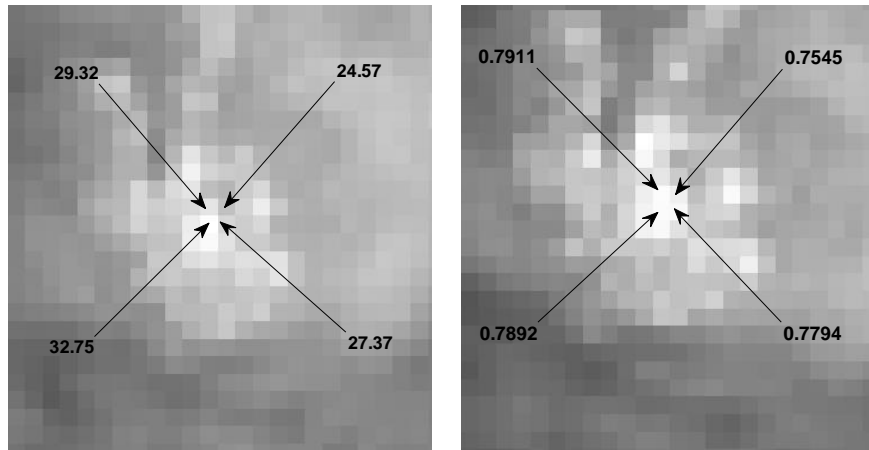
Variation in neighbouring pixel densities in units as: in Volpara® mm (left) and in SAR x-ray attenuation measure (right)
